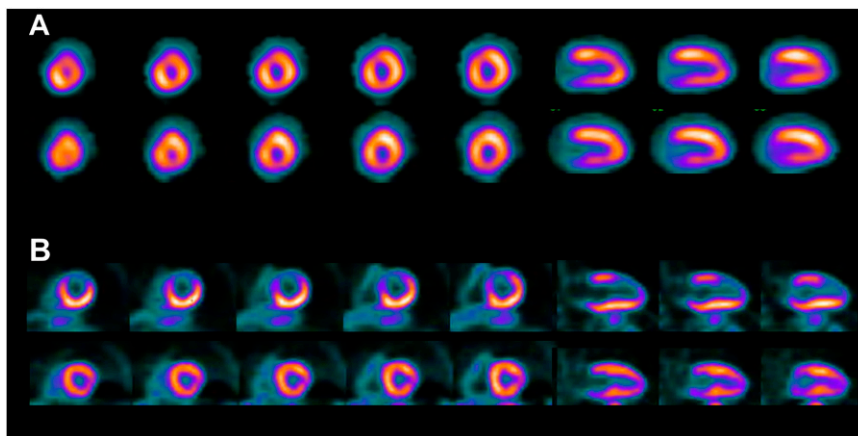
^{18}F -flurpiridaz phase 2 trial. 76-year-old man with significant left anterior descending defects on coronary angiography. Top rows: $^{99\text{m}}\text{Tc}$ SPECT; bottom row: ^{18}F -flurpiridaz PET. Overall image quality and resolution is superior with short-axis ^{18}F flurpiridaz PET. Severe anterior and anteroseptal defects were noted on PET, but SPECT also shows a small, mild anteroseptal defect.
